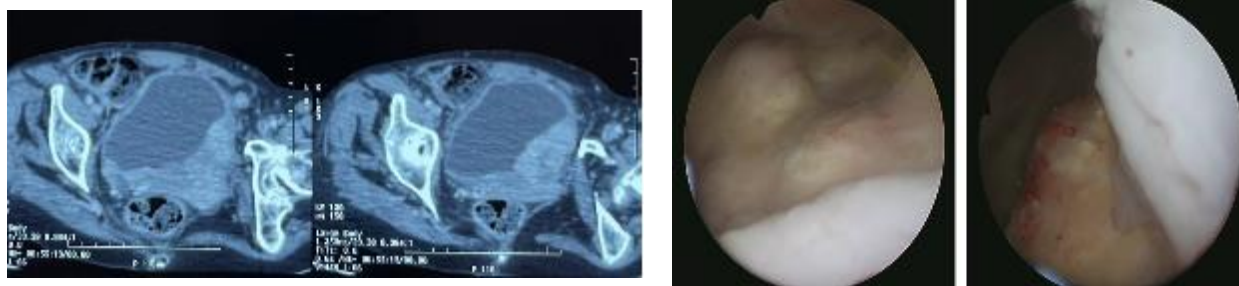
Radiologic and cystoscopic appearance of the lesion. Left: contrast-enhanced computed tomography showing an infiltrative bladder mass with bilateral obstructive uropathy. Right: cystoscopic view showing a solid infiltrative trigonal lesion extending to the left bladder wall and involving the ureteral orifices
